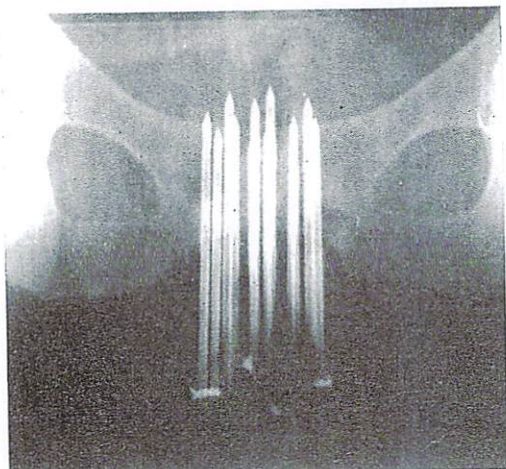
Verification radiograph before loading of the needles with inserts.
